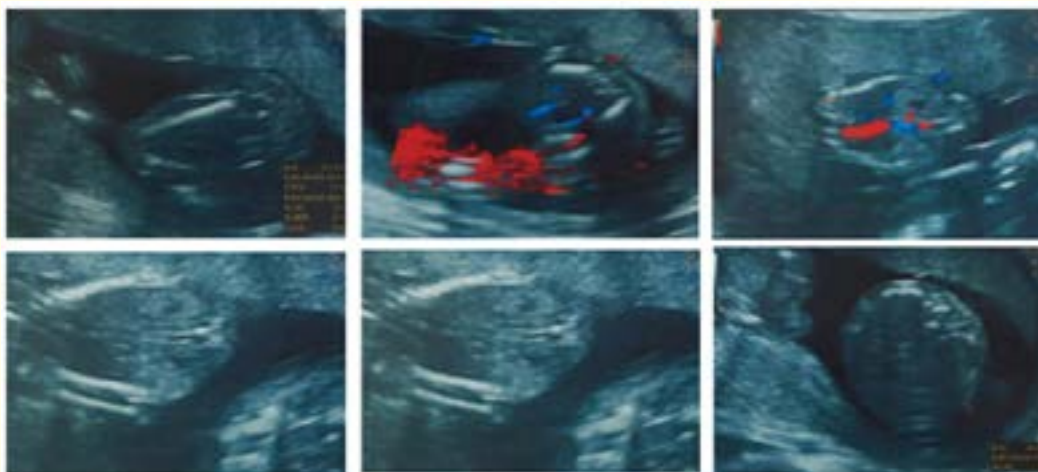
Pictures of the ultrasound taken at the anomalies board. Pictures taken with the patient's authorization.
